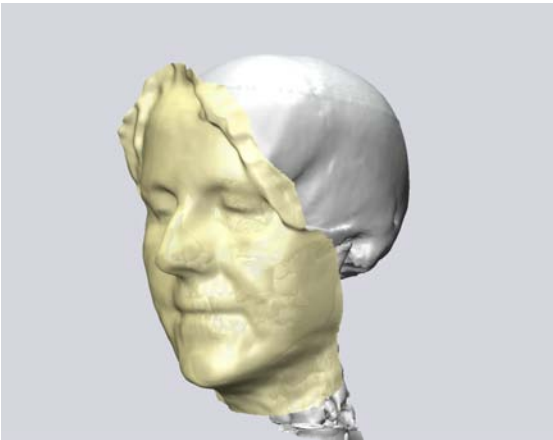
Resulting three-dimensional model as a combination of CT data with holographic surface data. The texture information is not shown in this figure.
